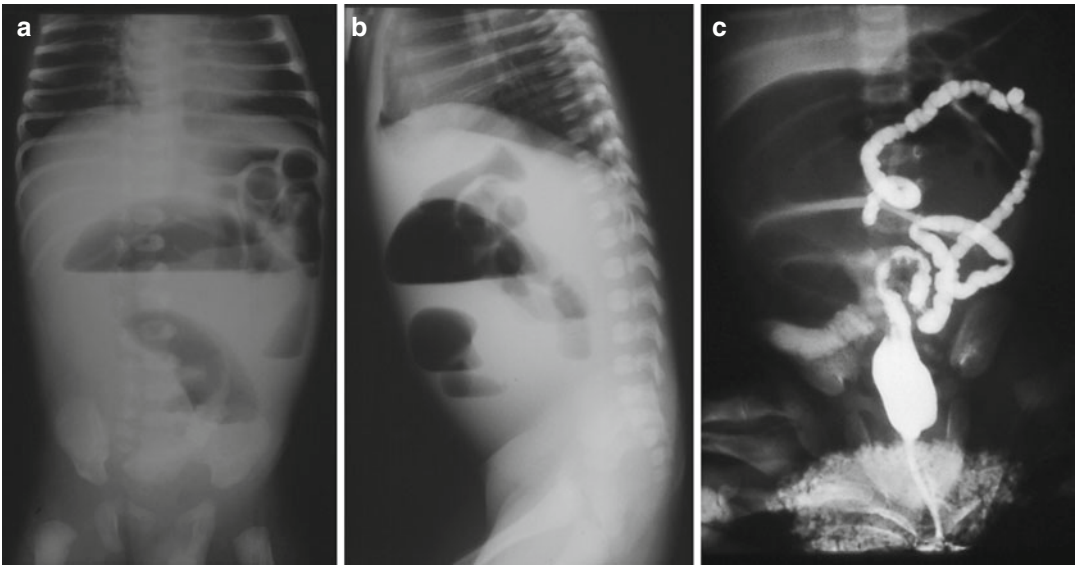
Multiple intestinal atresias. (a, b) Frontal and lateral radiographs show intestinal obstruction with air-fluid levels. (c) Barium enema study demonstrates an unused microcolon occupying the left abdomen
